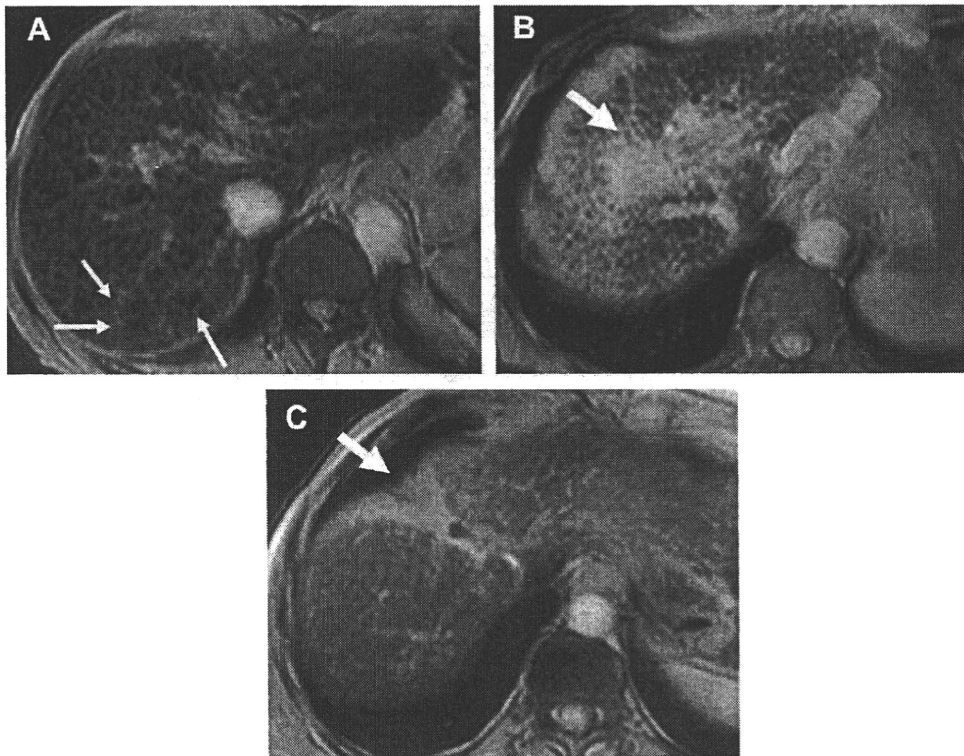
T2-weighted GRE image (TE, 9.5 ms) after administration of SPIO distinctly demonstrates high-intensity reticulations (A) (arrows) and confluent fibrosis (B = wedge shape, C = geographic shape) (arrow), which do not take up SPIO particles in cirrhotic liver with HCV.
